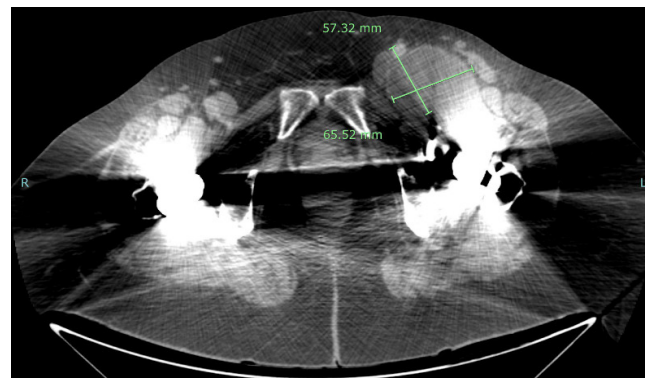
Axial View, CT imaging of abdomen and pelvis with left pseudotumor measuring 5.7 c x 6.5 cm anterior the left MoM hip implant.
